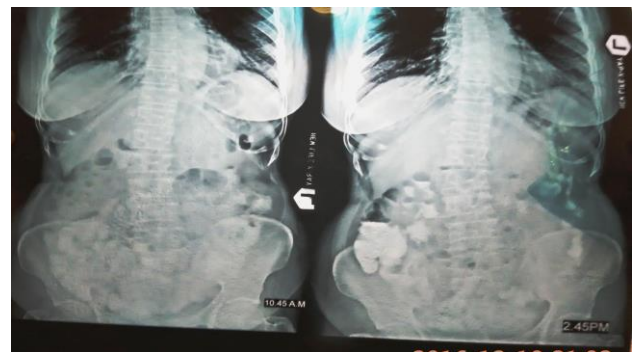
Serial X-ray in a patient of SBO taken after 1hr and 4hrs. second x-ray showing dye crossing the i-c valve.
